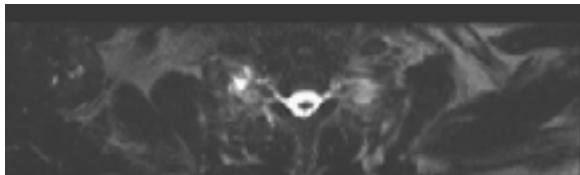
T2-weighted MRI revealed contrast enhancement along neural sleeves of C7-T1.
